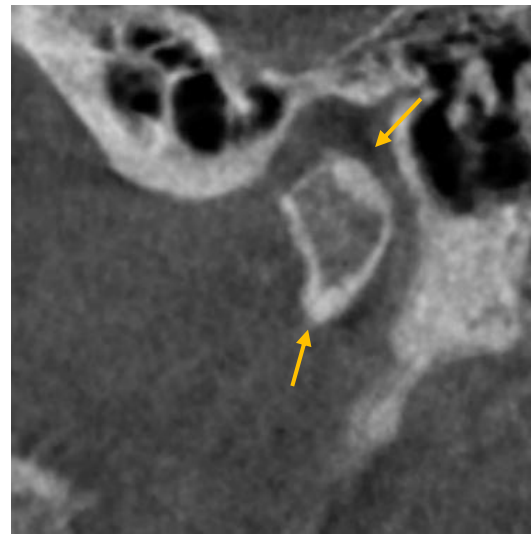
B. Corrected sagittal view of left condyle in sectional CBCT showing sclerosis.
